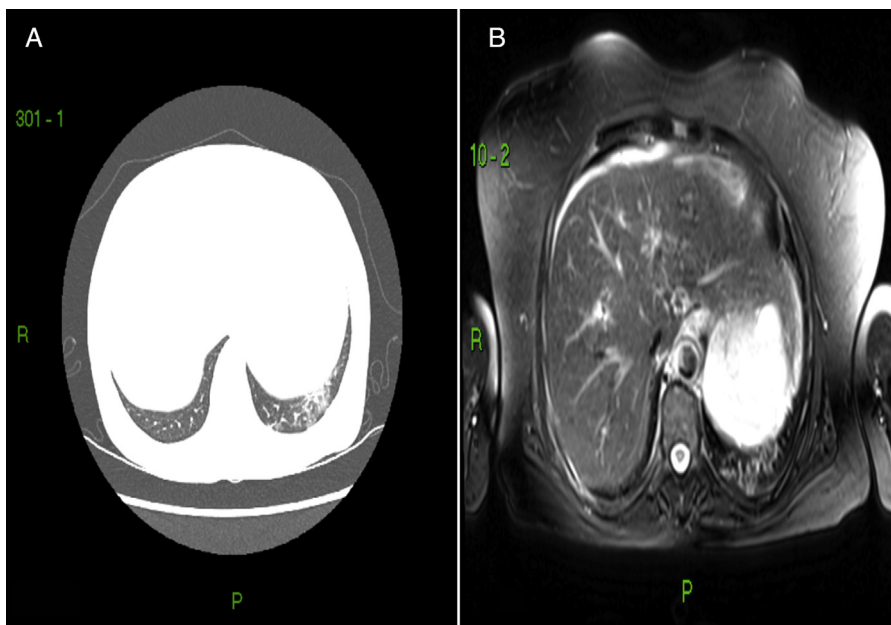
Respectively, chest CT and chest MRI of patient with SSc. A, shows ground-glass attenuation area in the lower lobe of the left lung; B, shows an area of T2 increase in the corresponding area.
